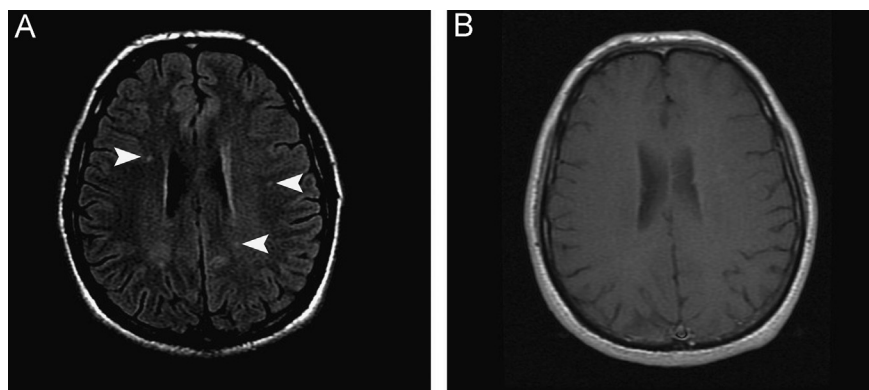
Brain MRI. (A) Axial fluid attenuation inversion recovery (FLAIR) sequence shows multiple demyelinating white matter lesions (arrowheads). None of the observed lesions enhance on the contrasted axial T1-weighted magnetic resonance image (B).
